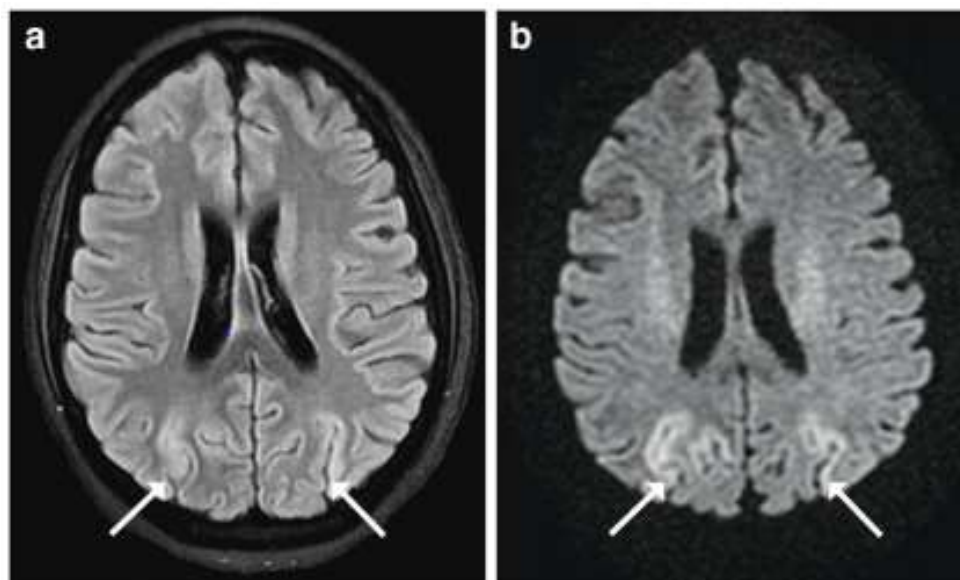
A 14-year-old girl initially presented with classic multisystem inflammatory syndrome in children (MIS-C) symptoms, including fever, abdominal pain, and myocardial dysfunction, alongside a positive COVID-19 serology. During hospitalization, she developed thrombotic microangiopathy with hemolytic anemia and altered mental status. Brain imaging findings: a, b: Axial FLAIR MRI (*a*) and corresponding diffusion-weighted imaging (*b*) at the level of the lateral ventricles and corona radiata reveal bilateral parieto-occipital cortical FLAIR hyperintensity with restricted diffusion, along with mild cortical thickening (arrows).[67].
